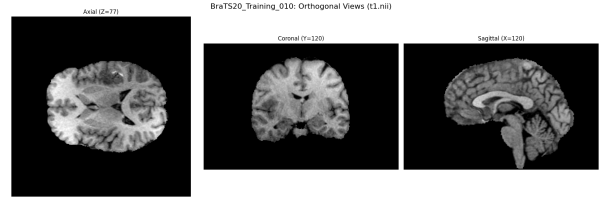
Standard anatomical views of a brain MRI (ordered accordingly): axial, coronal, and sagittal.
